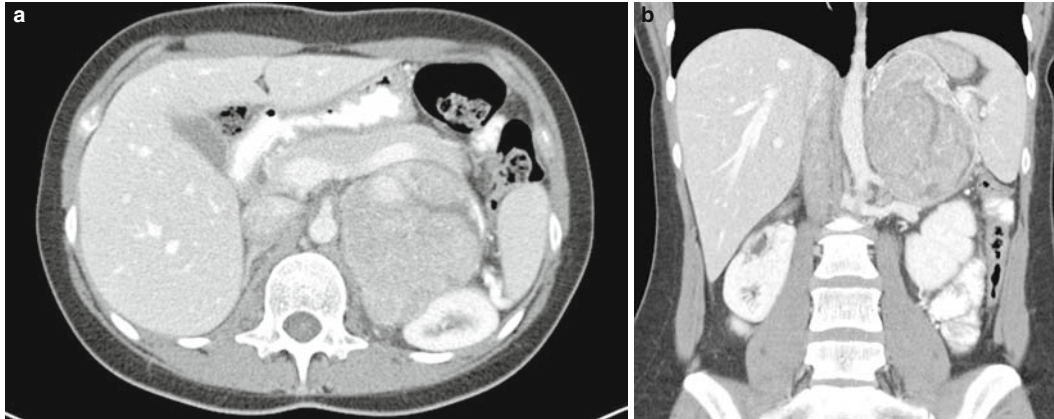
(A) An axial CT scan, demonstrating a 10-cm left pheochromocytoma with areas of central necrosis displacing the pancreas and splenic vasculature anteriorly. (B) A coronal CT image of the same pheochromocytoma consuming the left upper quadrant.
